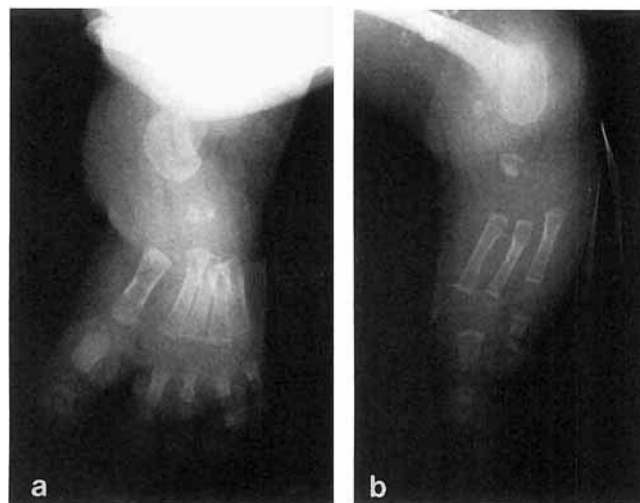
a: Radiograph of patient's left foot at 12 months. b: Radiograph of patient's right foot at 12 months.
